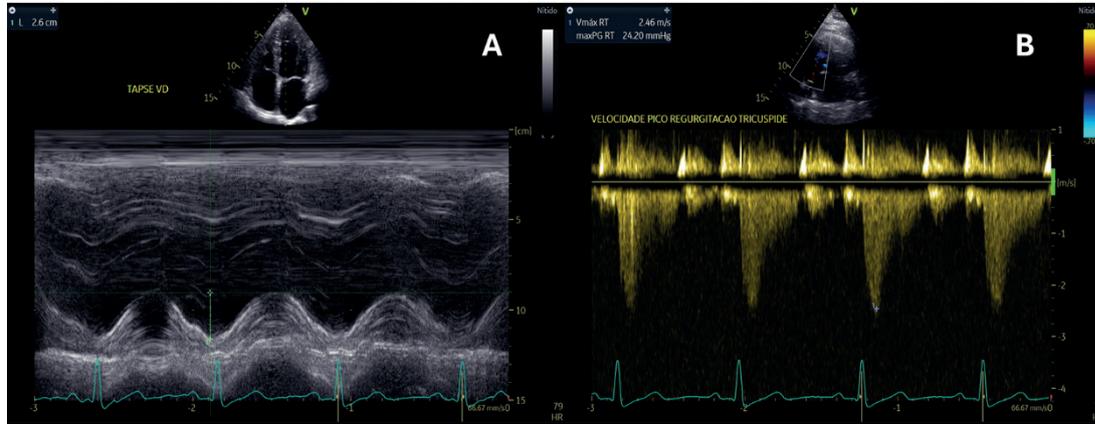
(A) Tricuspid annular displacement measured by M mode echocardiography - TAPSE. (B) Continuous Doppler spectral curve, demonstrating tricuspid regurgitation flow, allowing the systolic pressure in the pulmonary artery to be estimated. The TAPSE/PASP ratio estimates the value of RV-PA VAC. TAPSE: tricuspid annular plane systolic excursion; PASP: pulmonary artery systolic pressure; RV: right ventricle; PA: pulmonary artery.
